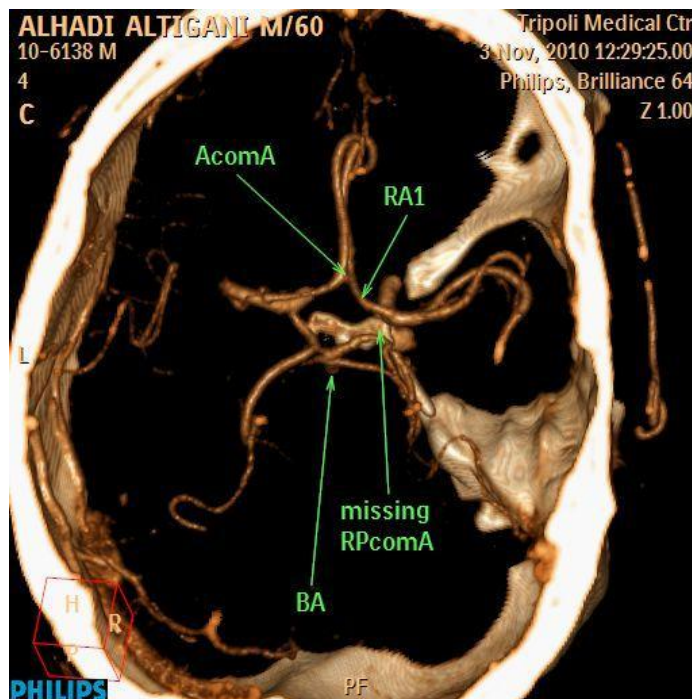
CTA shows Lt partial fetal type posterior circle of Willis and missing RPcomA.
